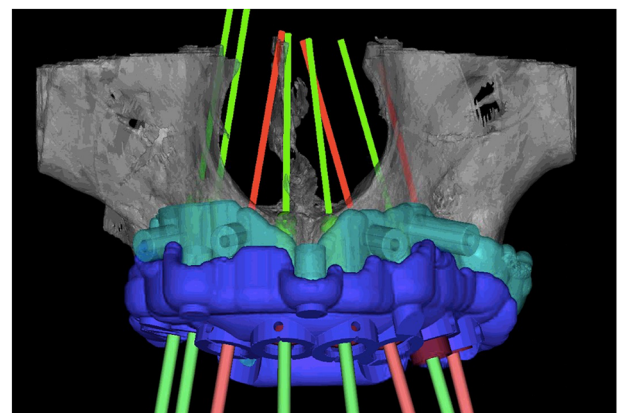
Virtual wax-up and implant planning. Since there was adequate bone volume according to the CBCT images in all implant sites, no bone grafting technique was required.
